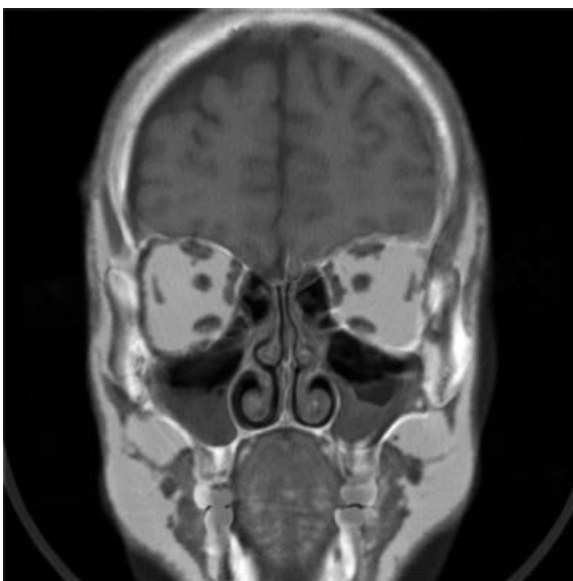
The digital fusion of the two previous images: the proper visualization of the spatial relationship of the delicate bony structures, better seen in CT, and soft tissues, better delineated in MR.
